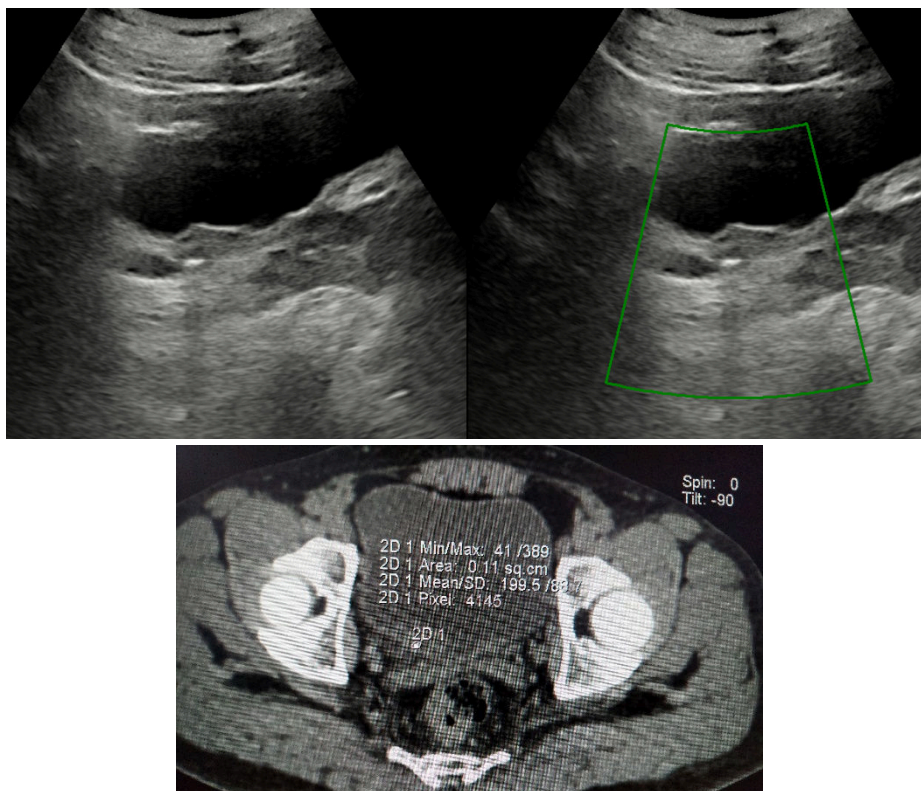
Figure I (A, B) : US (grey scale and colour doppler) as well as non-contrast CT showing calculus in the right vesico-ureteric junction which shows grade 0 twinkling artifact on doppler with mean HU of 199.
